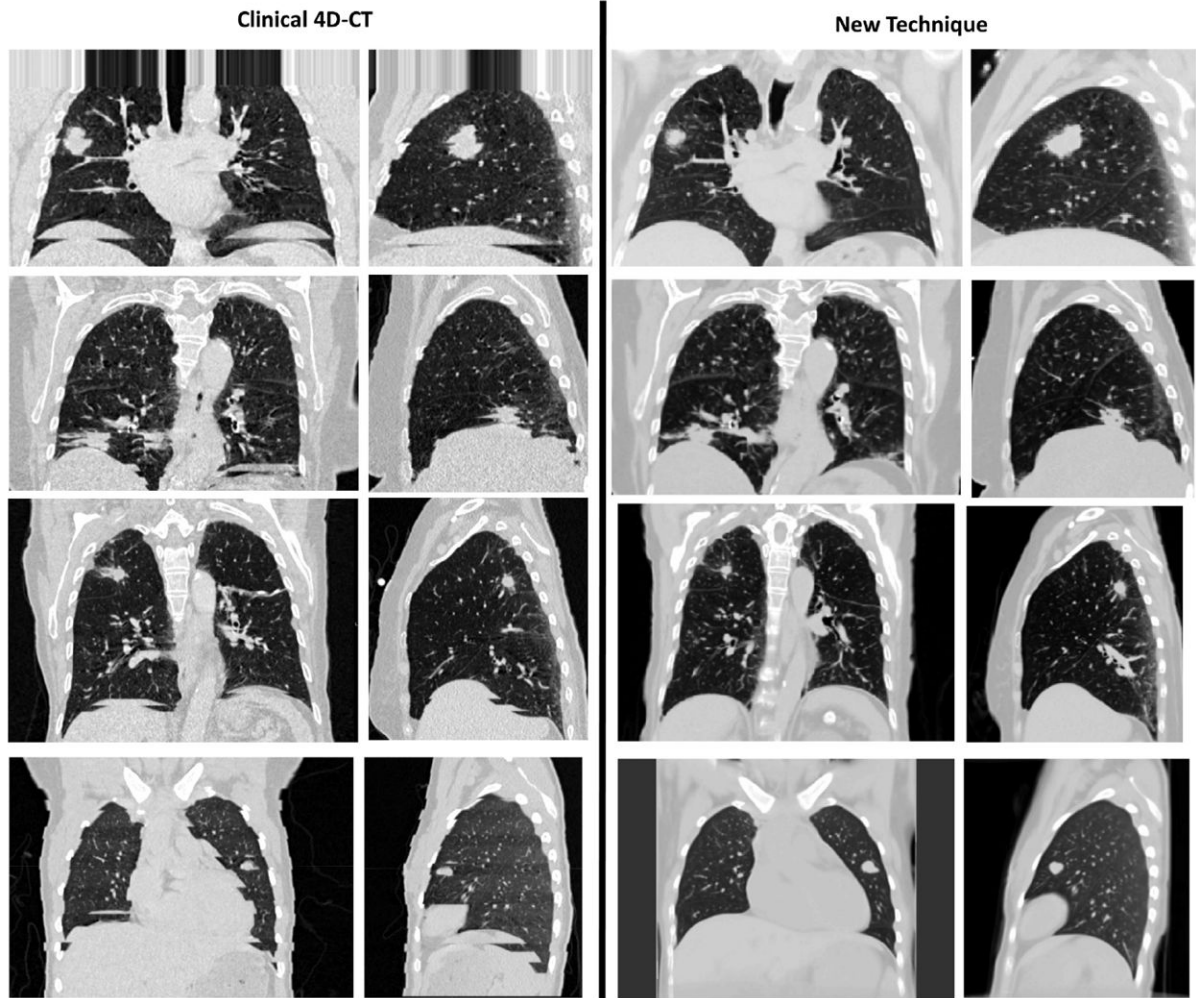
(Left column) Examples of clinical 4D-CT images are shown. (Right column) Sorting artifact-free image was generated by using the new 4D-CT method. Images at the 25th percentile tidal volume, central coronal slice, and right lung sagittal slice are shown in a lung window.
